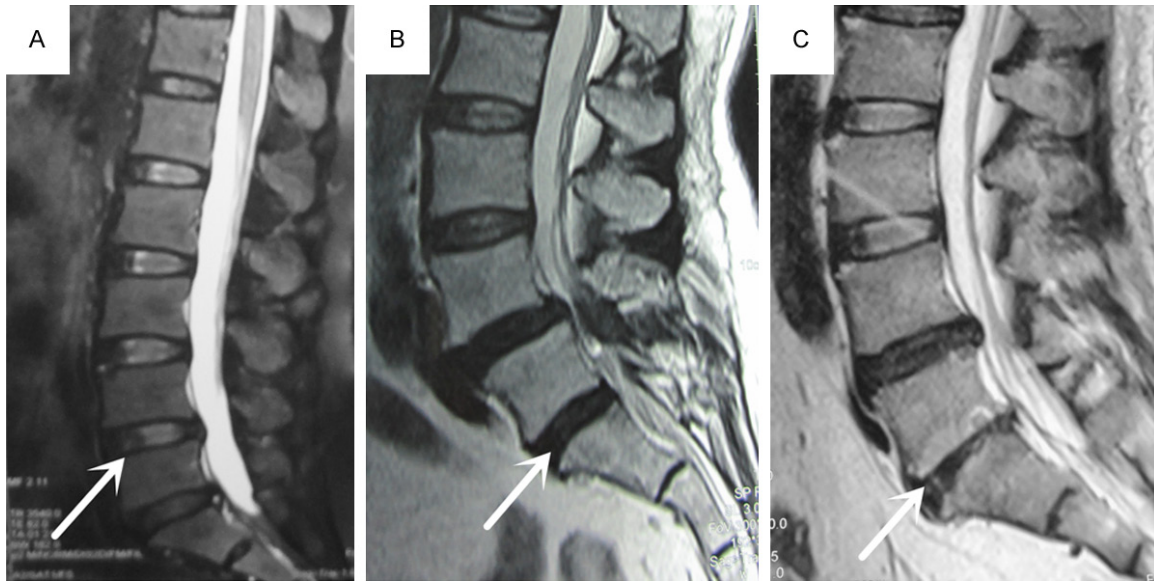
MR image of intervertebral discs classified according to the Pfirrmann grading system. (A) Grade III. (B) Grade IV, and (C) Grade V.
